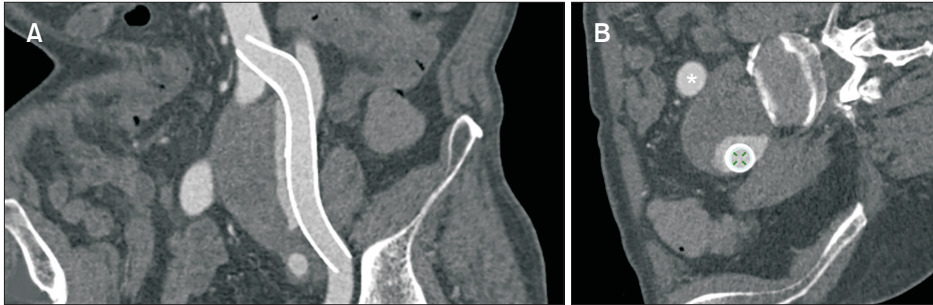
Computed tomography cross-section images. (A) Graft position, (B) internal iliac artery (asterisk) and external iliac artery with endoleak.
